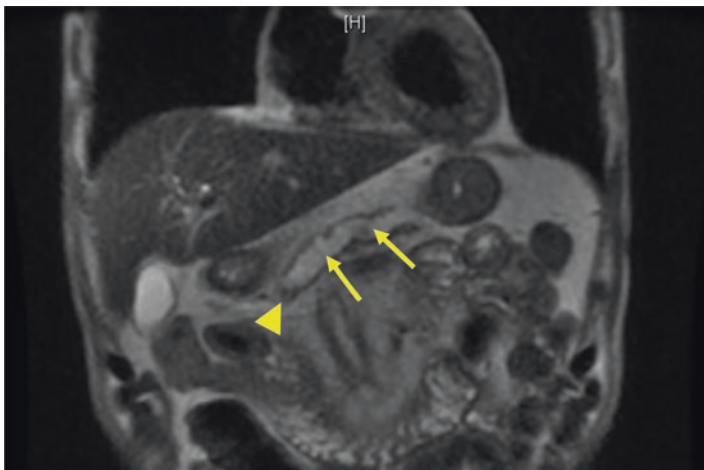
Coronal MRI/MRCP image demonstrating a markedly dilated main pancreatic duct (arrows) with stricture in the pancreatic duct in the head (arrowhead)
